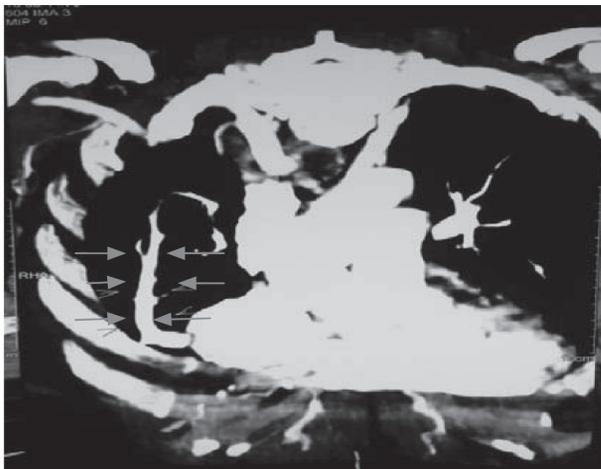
CT reconstructed image clearly showing the abnormal right pulmonary vein draining into the inferior venacava , the characteristic 'scimitar sign'.
